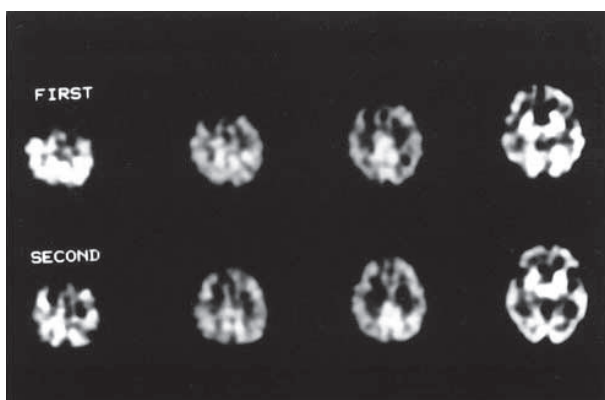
The first SPECT images (before donepezil therapy) showed decreased perfusion in bilateral frontoparietal cortex (upper images). The second SPECT during donepezil showed markedly increased perfusion in bilateral frontoparietal cortex (lower images).
